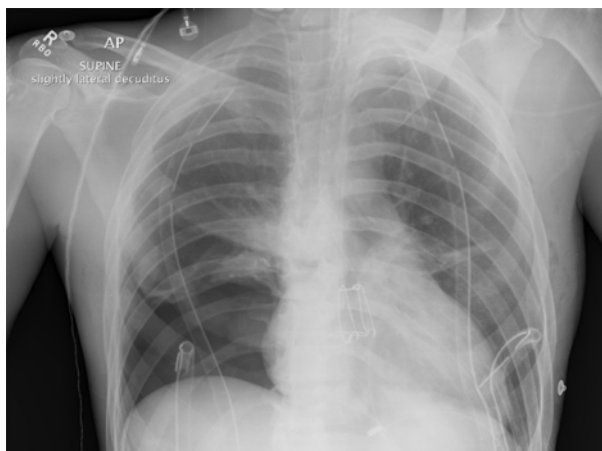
Serial chest x-rays in a patient who underwent lung resection
